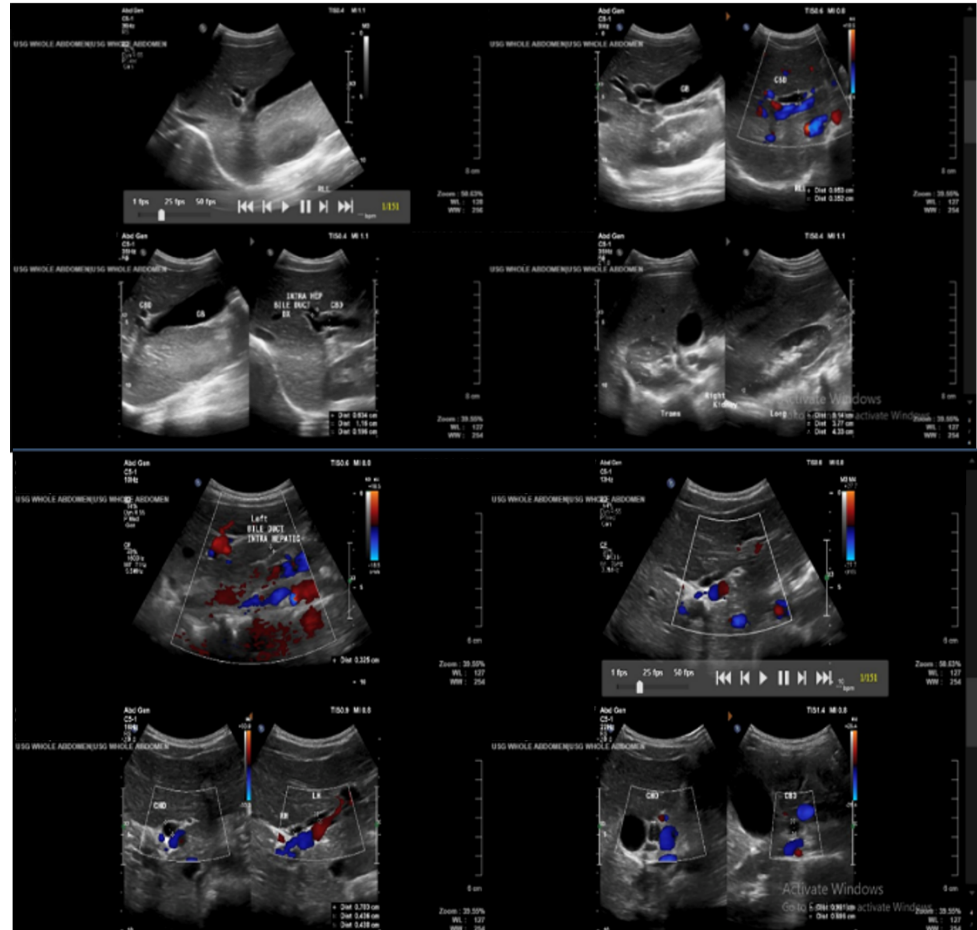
Abdominal ultrasound findings
